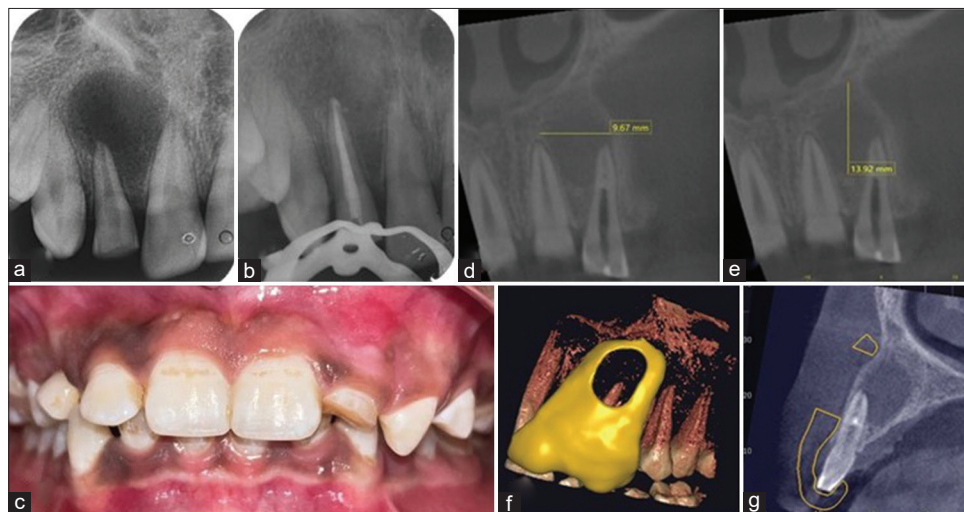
(a) Preoperative periapical radiograph, (b) Orthograde Mineral Trioxide Aggregate Obturation i.r.t. 22, (c) Preoperative intraoral clinical photograph, (d and e) shows the cone-beam computed tomography (CBCT) slices depicting extension of the lesion in all view, (f and g) shows planning of three-dimensional printed template using CBCT imaging
